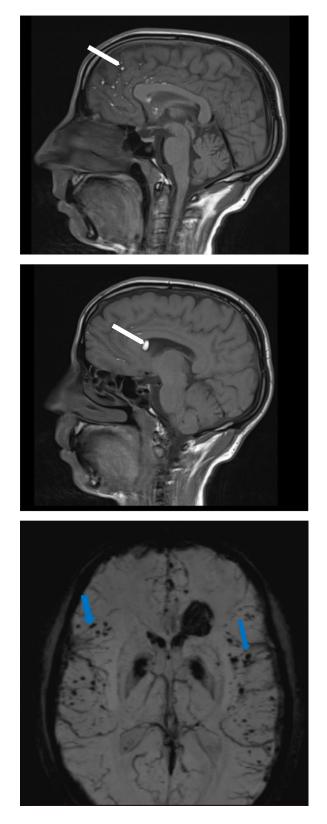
Sagittal section on T1-weighted sequence showing several pinpoint-like formations with hypersignal (White arrow), and with a signal on SWI with <
